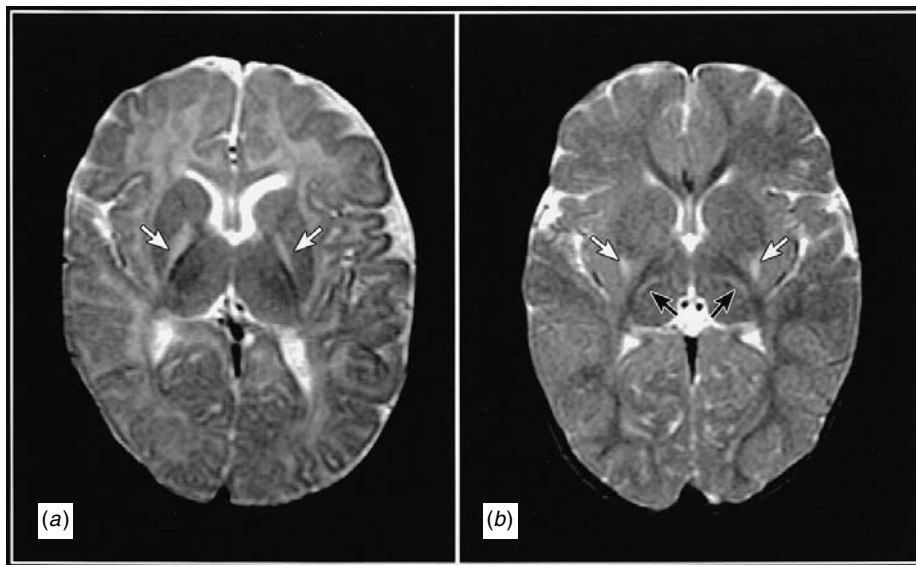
MR images from two infants with clinically similar neonatal encephalopathies, including seizures and ventilatory failure. (a) Globus pallidus hyperintensities (white arrows) seen in bilirubin encephalopathy; (b) Putaminal (white arrows) and thalamic (black arrows) hyperintensities seen in perinatal hypoxic-ischemic encephalopathy. Both result in extrapyramidal CP.
